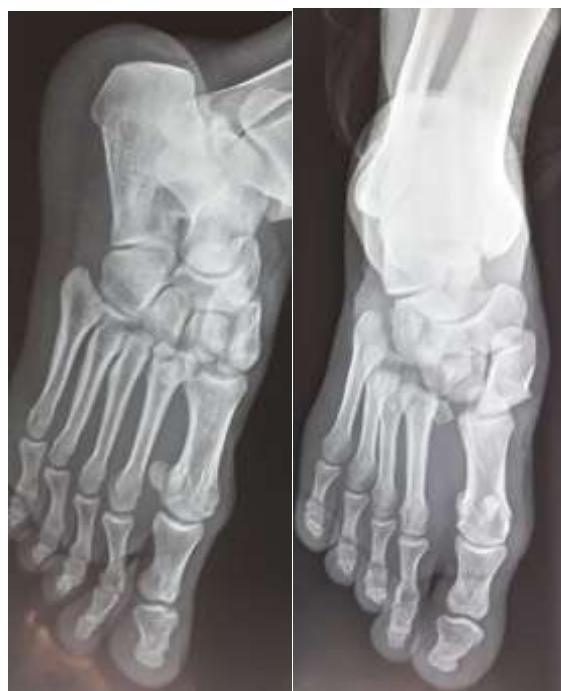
(a, b): A standard X-ray of Face and 3/4 of the right foot showing a fracture dislocation type A of Lisfranc according to Mayerson classification
